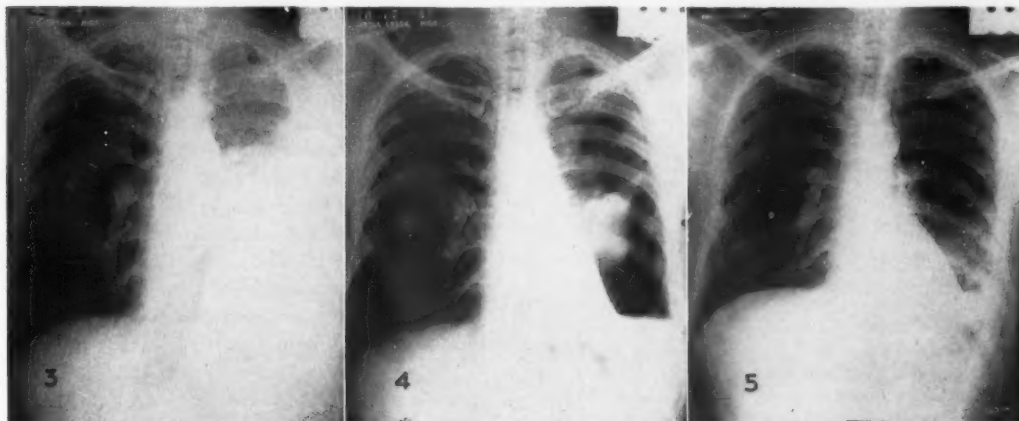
(Case 2). Chest roentgenogram taken on admission (October 8, 1951) showing large collection of fluid in the left hemithorax.
